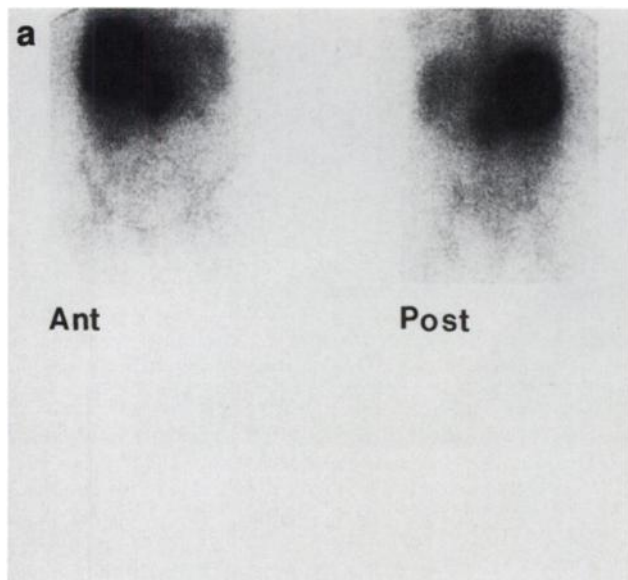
A 46-yr-old female with NHL with liver involvement and pelvic lymphadenopathy. (a) Gallium-67 abdominal images show abnormal increased activity in the liver. (b) CT after intravenous injection of contrast material shows a large, multilobulated hepatic mass (arrows). After three chemotherapeutic courses ^{67}Ga scintigraphy (c) shows no focal abnormalities and (d) CT shows a significant decrease in the size of the hepatic mass, but a residual mass is still noted (open arrow). The patient achieved complete response and has been free of disease for 18 mo after completing chemotherapy.
